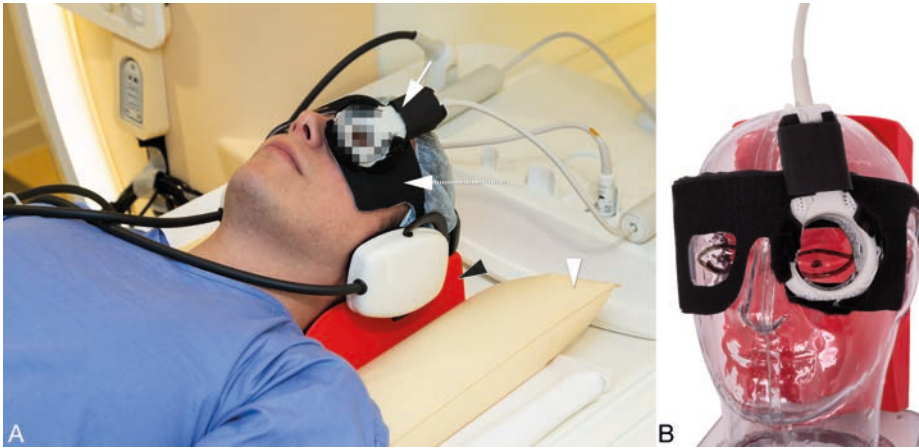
A-B. Clinical setup for ocular MRI.
